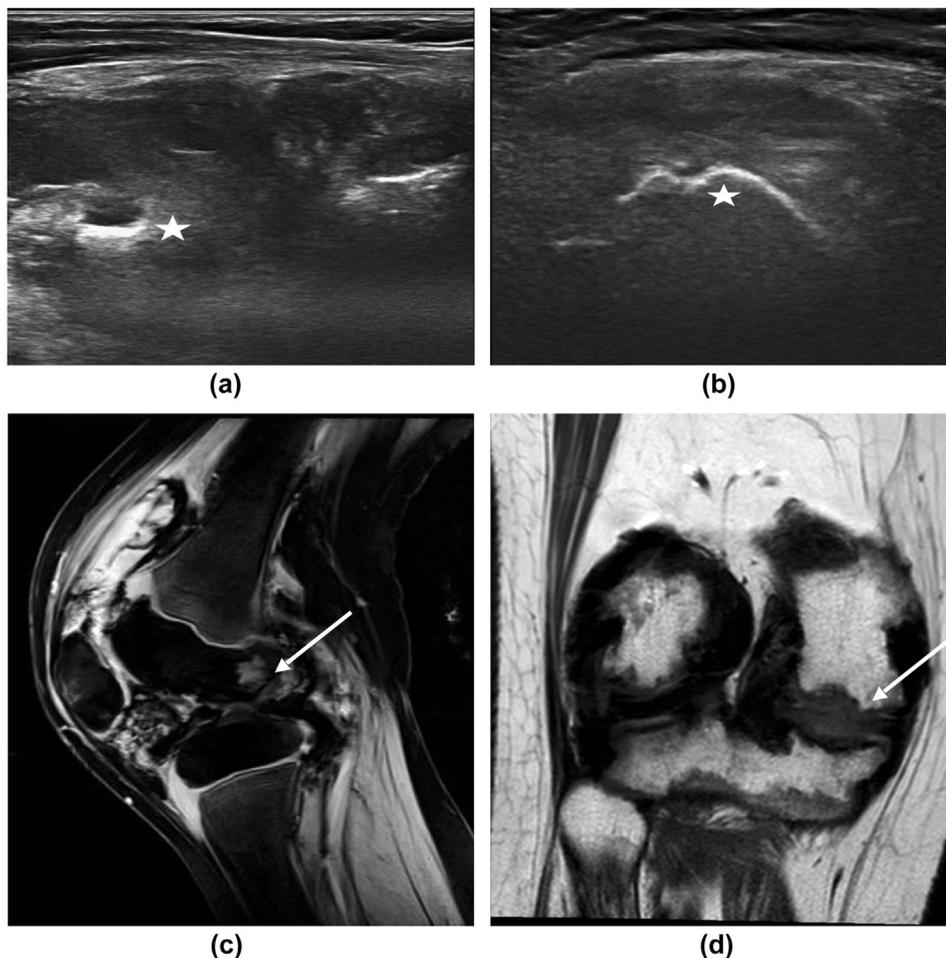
An 8-year-old boy with known haemophilic arthropathy of the left knee with a severe HJHS score of 14, underwent musculoskeletal US (US-US protocol), which revealed erosions (white asterisk) in the posterior sagittal medial (a) and posterior sagittal lateral (b) views and were further confirmed with MRI in the gradient sagittal (c) and T2 coronal (d) images (white arrows).
